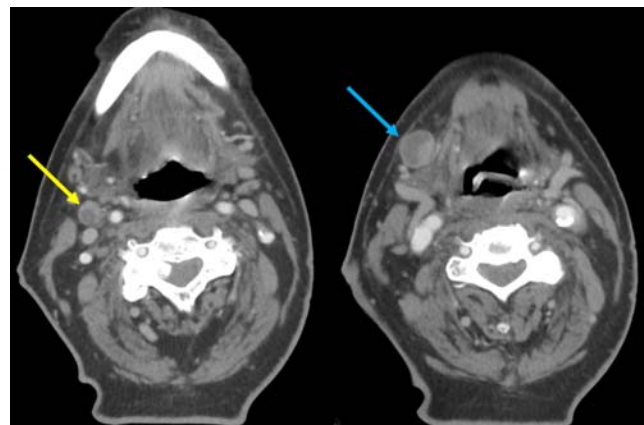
CT of the neck demonstrates pathologic lymph nodes in the right upper neck, level 2A (yellow arrow), and right submandibular region, level 1B (blue arrow). Image courtesy of the University of Massachusetts Medical School, Department of Radiology.
